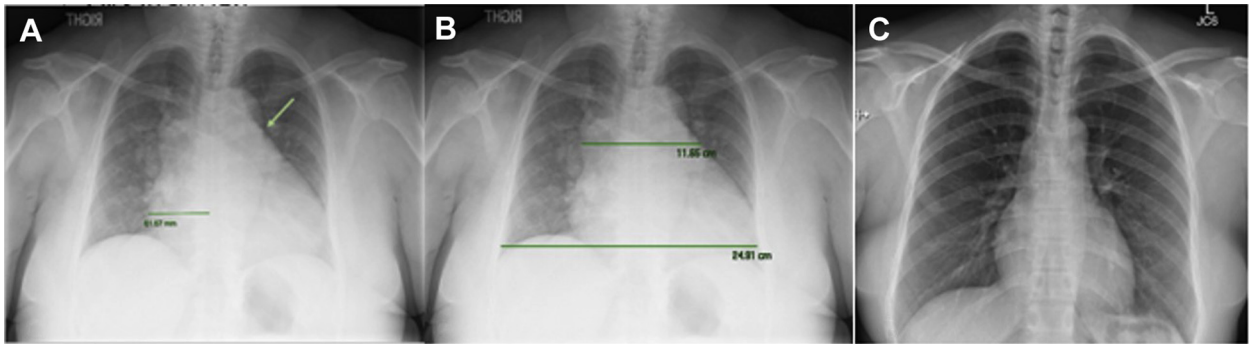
Frontal chest radiograph demonstrating right atrial enlargement. A, From the midline to the right heart border is measured to be 61 mm (>44 is abnormal). Also noted is oblique edge due to engorgement of the pulmonary artery (thin arrow) and left ventricular enlargement. B, Increase in the hilar to thoracic ratio of 0.47 (>0.44 is abnormal). This can be compared to a normal frontal chest radiograph (C).
